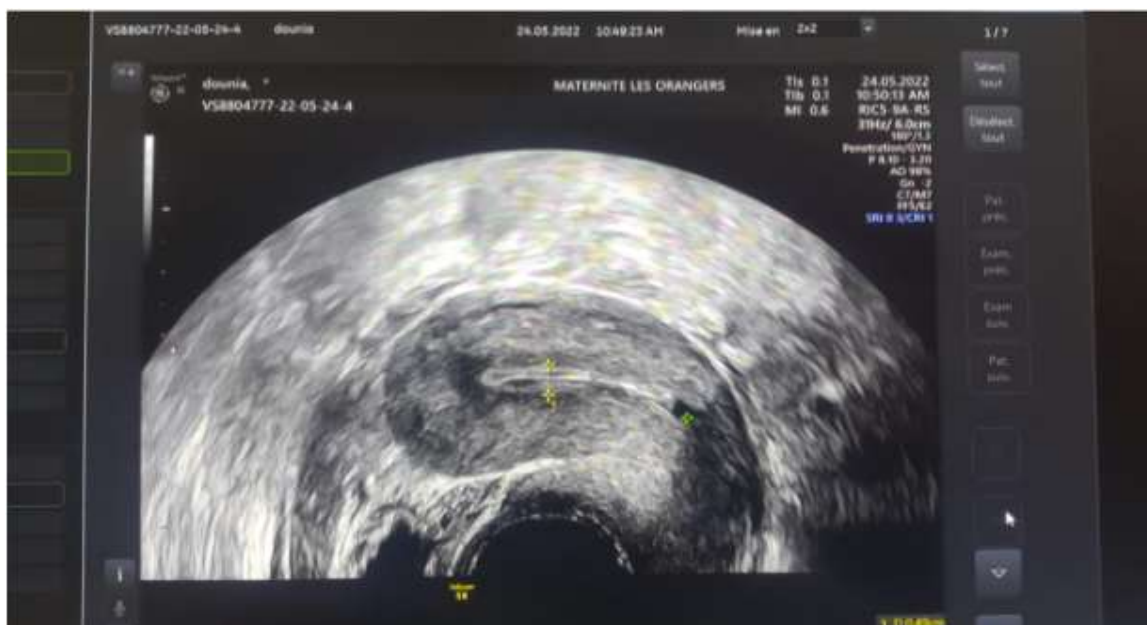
The two-Dimensional Pelvic Ultrasound, Sagittal Section of The Uterus Without Abnormalities.
